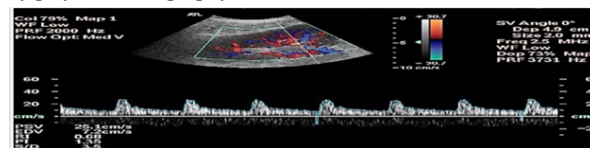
Doppler and color perfusion of post transplant renal allograft.
